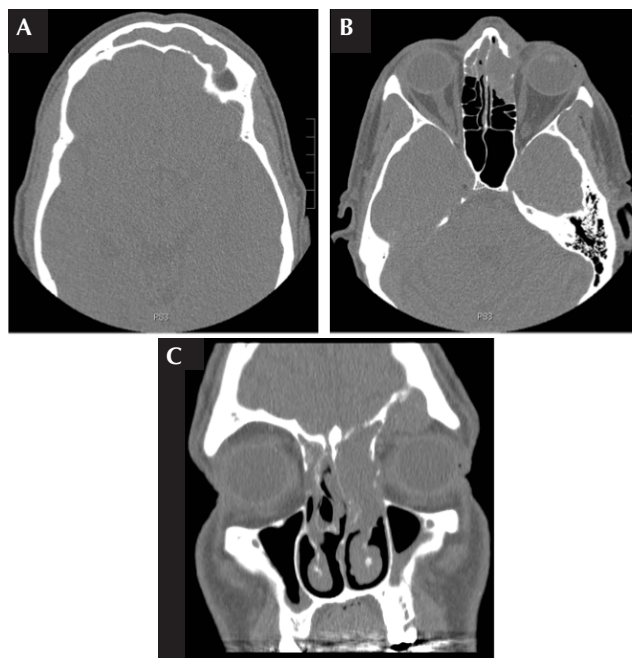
Patient's computed tomography imaging on initial presentation. (A) Axial image demonstrating opacification of the frontal sinus, with erosion and partial bone destruction involving the anterior and posterior tables of the left frontal sinus, creating microperforations to the anterior cranial fossa. (B) Axial image demonstrating erosion of the left lamina papyracea. (C) Coronal image demonstrating inferomedial displacement of the left globe from tumour mass extension into the orbit.
